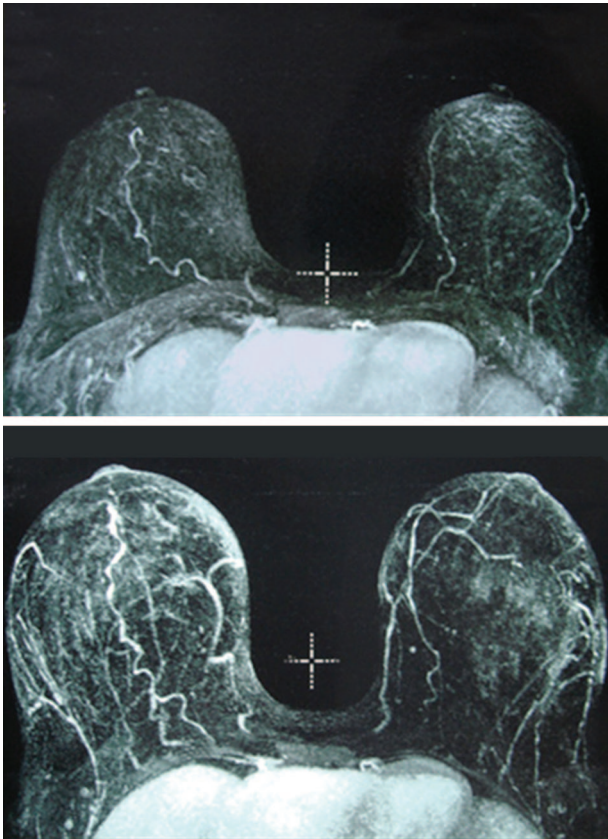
Magnetic resonance imaging scans of breasts with contrast in a patient before (*above*) and after 3 weeks of 10 hours/day of Brava use (*below*). Note the enlarged parenchyma and the marked increased vascularity in the image *below* (after Brava use).
